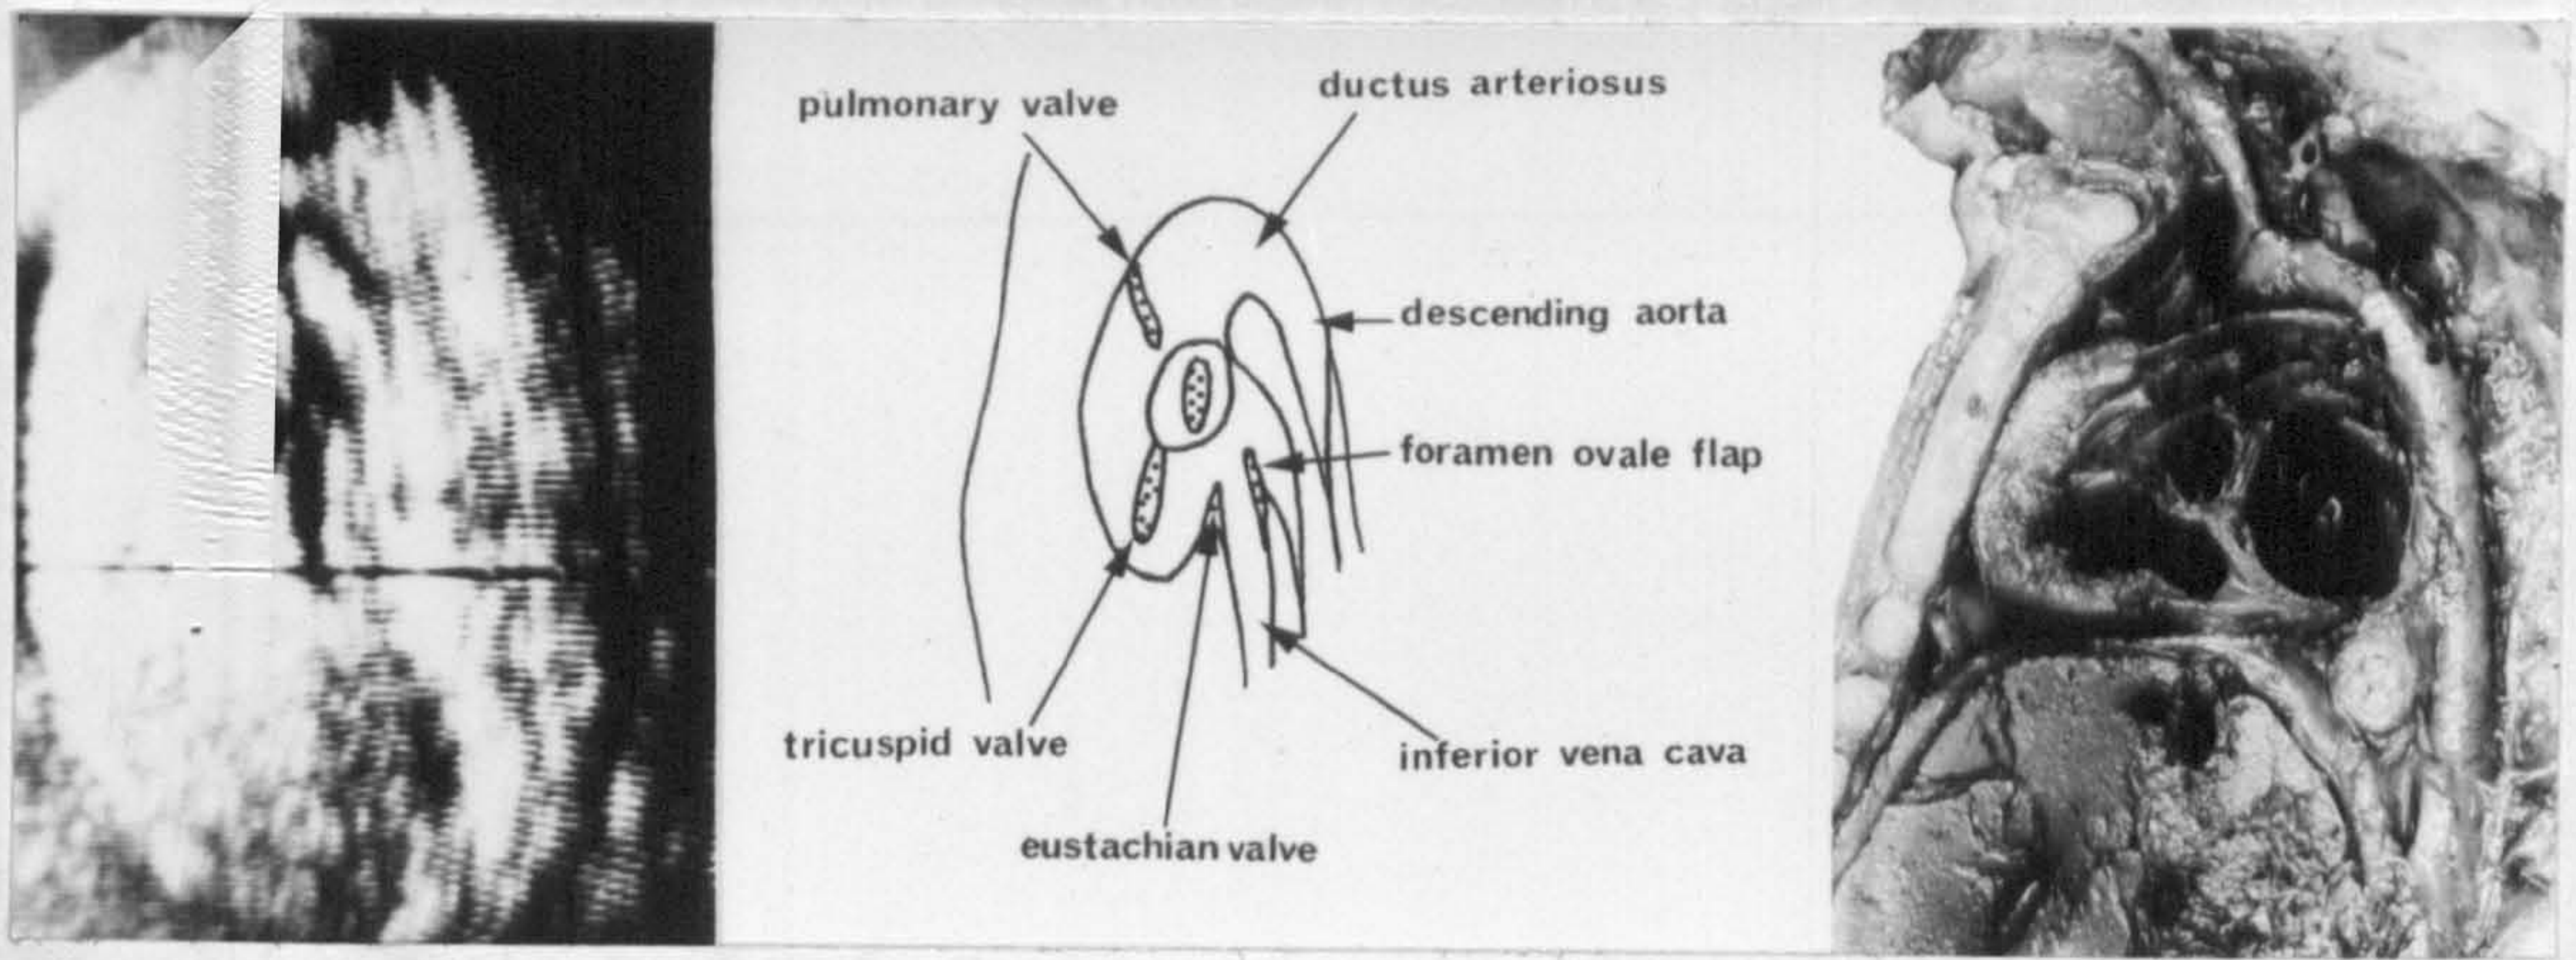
Ductal plane displayed echocardiographically and anatomically. The aorta and valve closure line is seen as a circle in the centre. The inferior vena cava can be seen entering the right atrium. The tricuspid valve, pulmonary outflow tract, pulmonary valve, pulmonary artery and ductus arteriosus connecting to the descending aorta are also seen in this plane.
